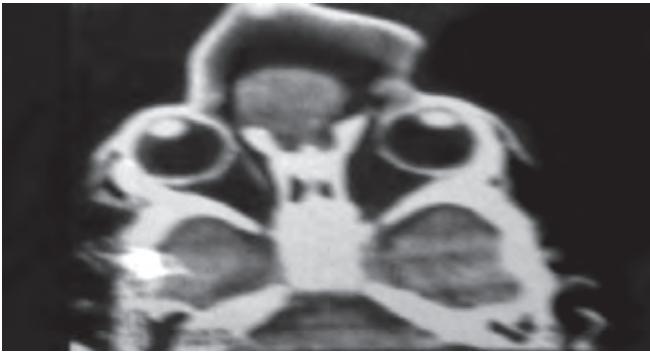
CT scan axial cut of a child with nasoethmoid encephalocele with gross hypertelorism
